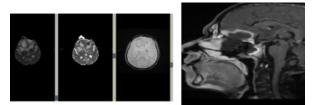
(a) Fungal abscess in both frontal lobe showing restricted diffusion in the periphery and intracavitary projections on DWI and ADC sequence and blooming on GRE sequence. (b) Non enhancing middle turbinate due to necrosis and appearing as black turbinate.
